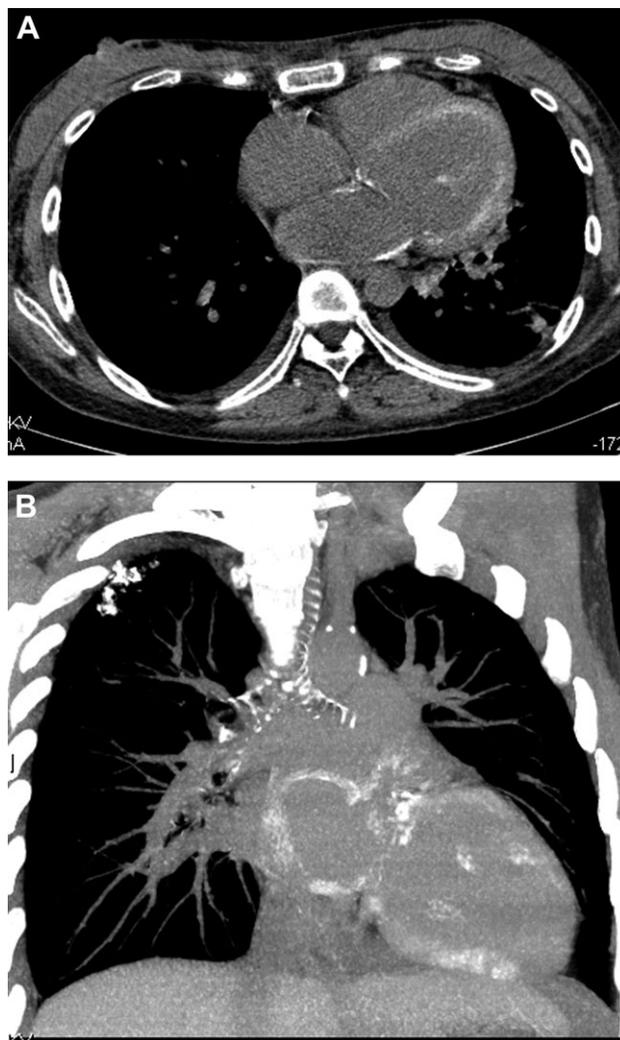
CT images showing left atrium and ventricle dilatation (A) and myocardium, lung and coronary arteries calcification (B).
